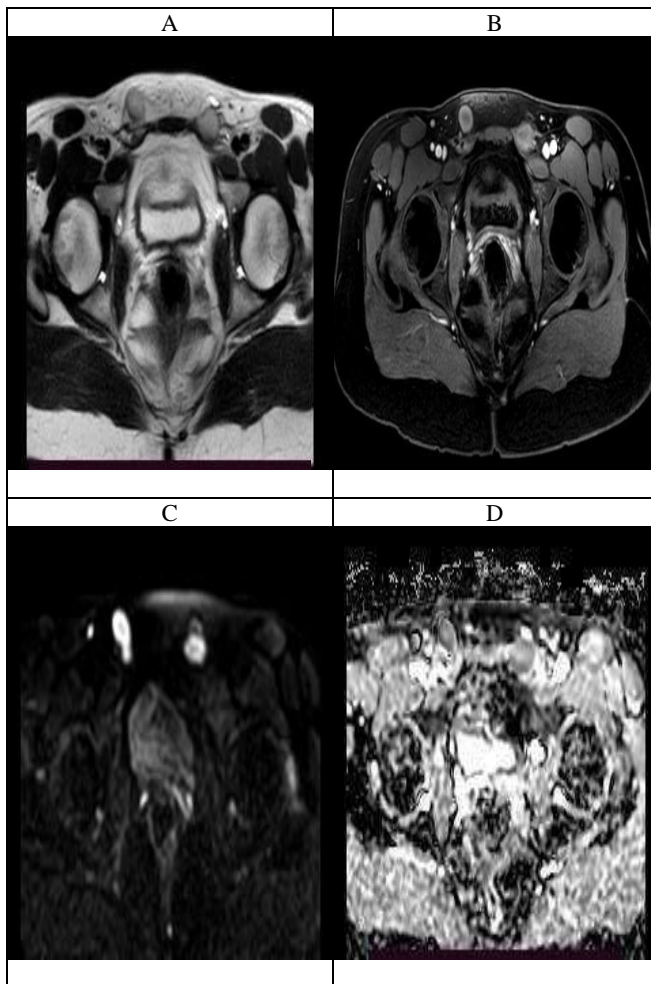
Pelvic MRI: (A) T2 WI axial cut (B) Post contrast image axial cut (C) DWI and ADC maps axial cuts. They show bilateral oval shaped structures seen in the proximal part of each inguinal canal which exhibit heterogenous signal intensity slightly hypointense in T2WI(A) restricted pattern in DWI and ADC maps (C and D) and heterogenous enhancement on post contrast images which mostly represents bilateral undescended testes.
